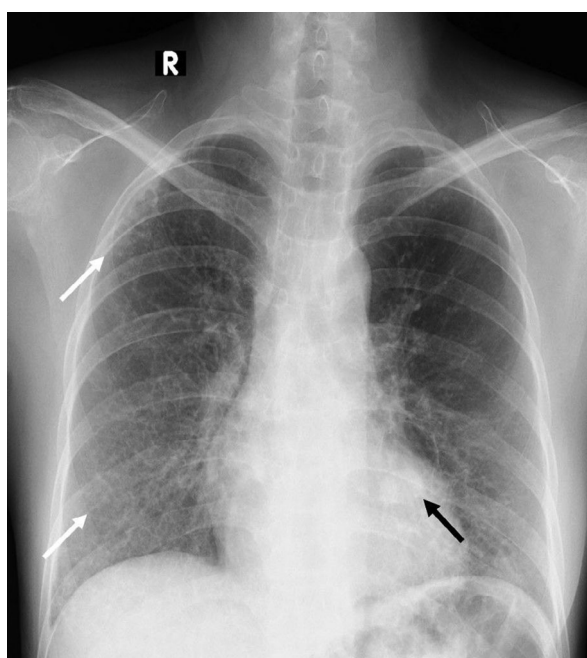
Chest x-ray (posteroanterior view) revealed a well-defined homogeneous opacity in the left lower lung zone (black arrow). Extensive reticular opacity and honeycombing (white arrows) involving both uppers and lower zones were also noted
